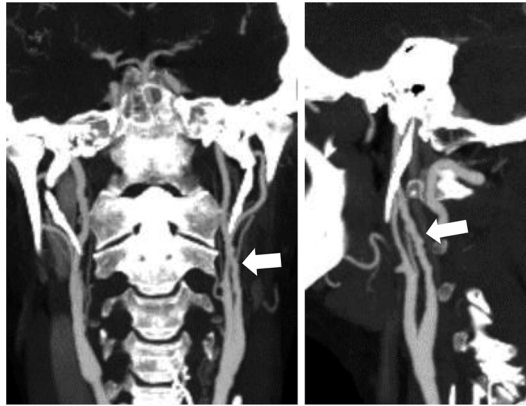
Fibromuscular dysplasia, bilaterally ICA (white arrows), CTA coronal view (left) and sagittal view, left ICA (right).
